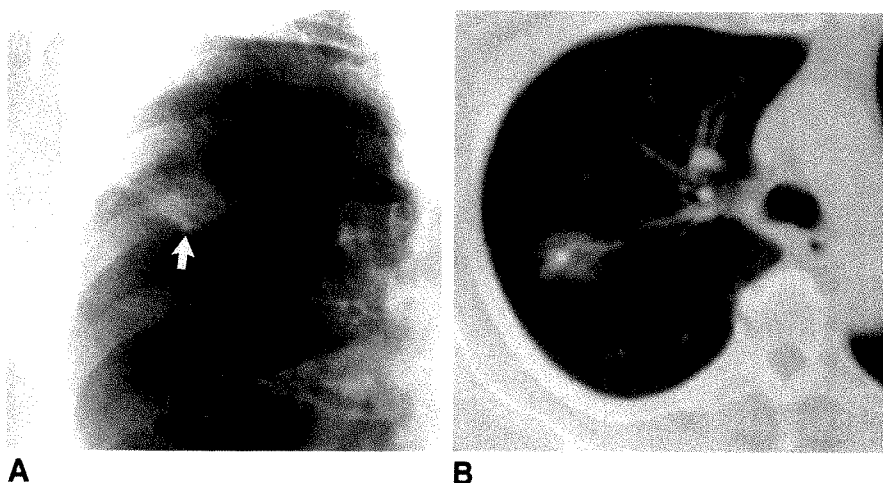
A and B, Some patterns of benign (A) and "malignant" (B) calcification seen on plain radiographs or CT scans can be helpful in predicting that a lung nodule is benign. Malignant patterns can be seen with either benign or malignant lesions.
